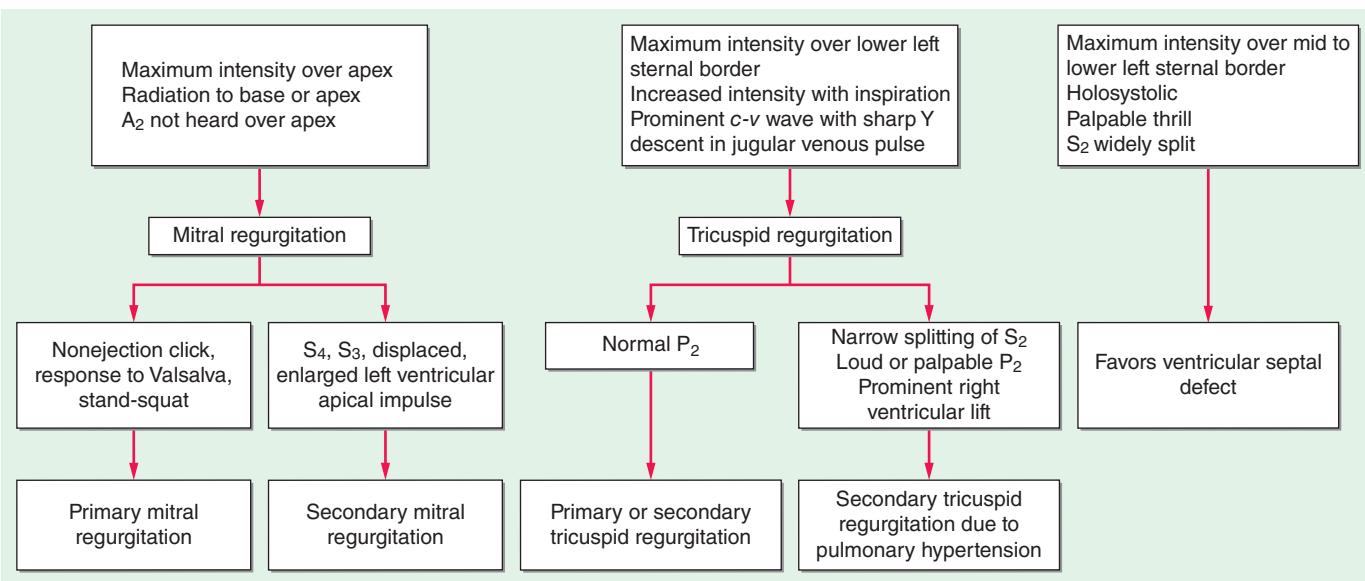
Differential diagnosis of a holosystolic murmur. The murmur of mitral regurgitation is best heard over the left ventricular apex. The radiation of the murmur depends on the direction in which the jet of mitral regurgitation enters into the left atrium. Differentiation of primary and secondary causes of mitral regurgitation is usually accomplished with transthoracic echocardiography, although the presence of a nonejection click and a mid-late apical systolic murmur, for example, can establish a bedside diagnosis of mitral valve prolapse (primary mitral regurgitation). Secondary mitral regurgitation can occur as a result of left ventricular remodeling. The murmur may be soft and difficult to hear. Other signs of left ventricular dysfunction may be present. Greater than 80% of the tricuspid regurgitation encountered clinically is due to a secondary cause. Severe pulmonary hypertension can be appreciated by a loud, single P₂. Primary tricuspid regurgitation may be present in the setting of pacemaker leads or in patients with carcinoid syndrome who usually have signs of liver involvement. A ventricular septal defect is usually manifested by a holosystolic murmur with a palpable thrill along the mid- to lower left sternal edge.
